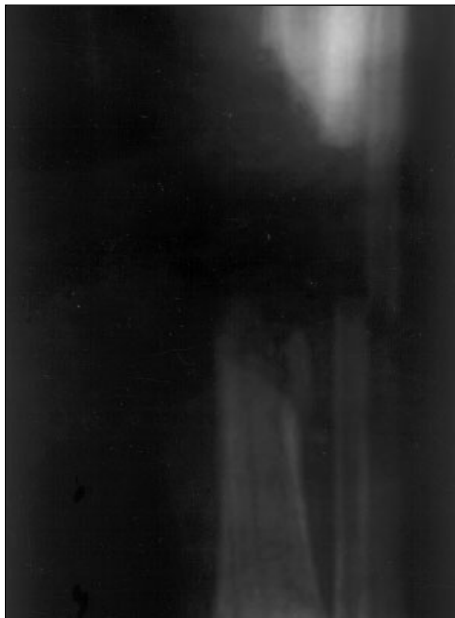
Radiograph at admission showing extent of skeletal disruption
